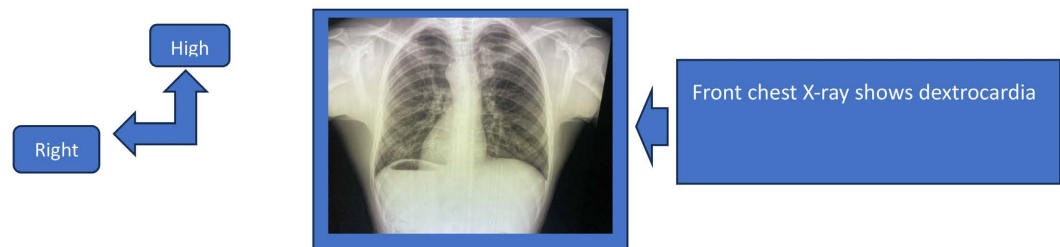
Front chest X-ray.
